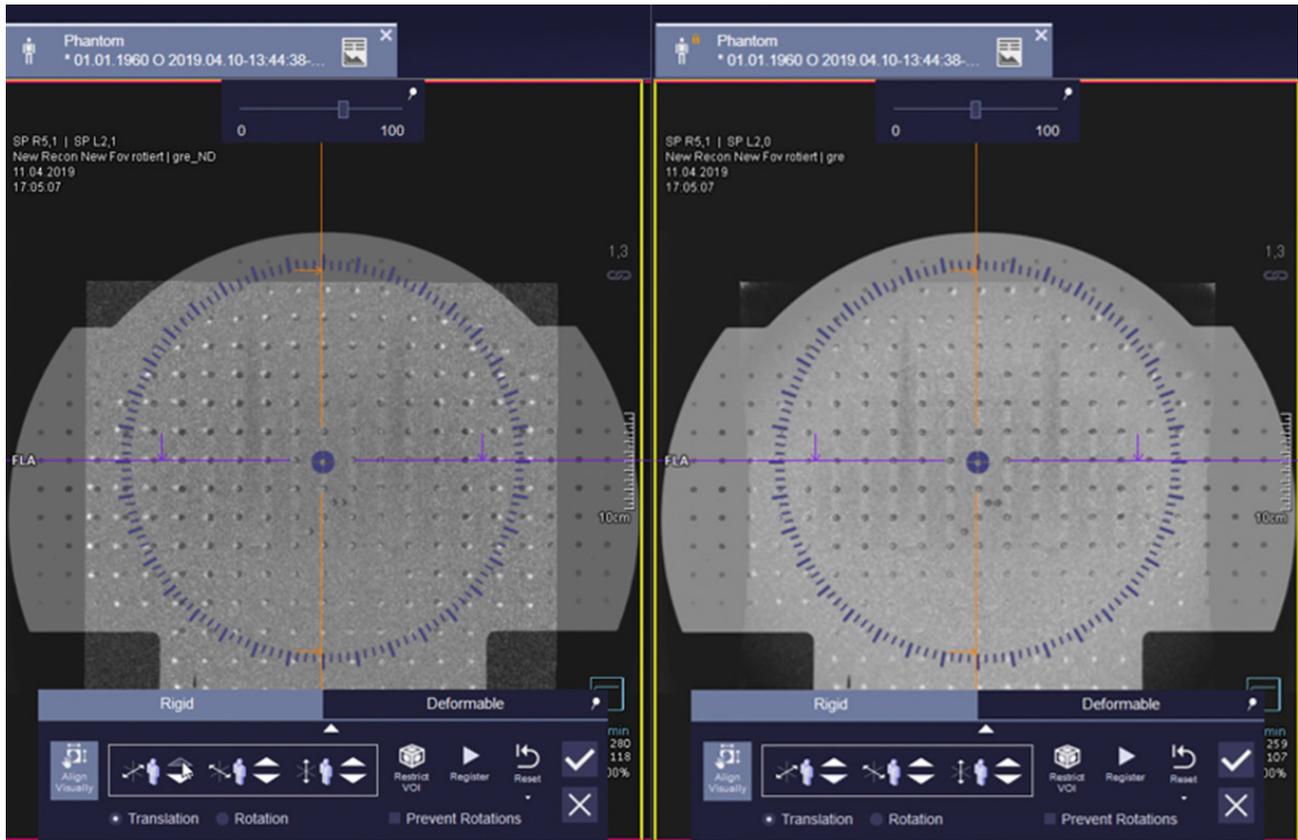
Visual comparison of residual distortion, visualized on rigidly fused CT and MR, without (left) and with (right) distortion correction switched on, in syngo.via RT Image Suite
